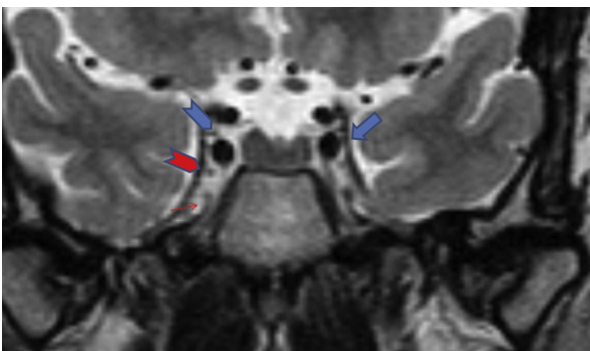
Coronal, T2-weighted sequence through the CS. The oculomotor nerve (arrowhead), trochlear nerve (blue arrow), and abducens nerve (red arrowhead) are seen within the CS. The exiting mandibular nerve (red arrow) is also seen although it is not within the CS.
